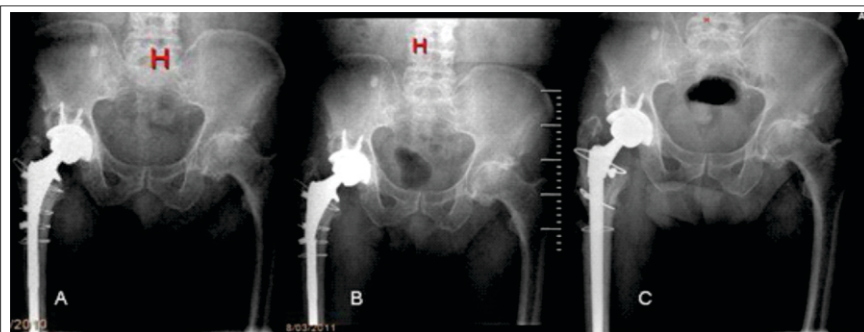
Radiological evolution after revision surgery; X-ray AP views: 1.A.) 1 year after primary hip arthroplasty revision; 1.B.) 25 months after hip revision; the femoral stem fracture can be observed at the junction of the proximal and the middle third; 1.C.) 1 year after revision of the fatigued femoral stem
